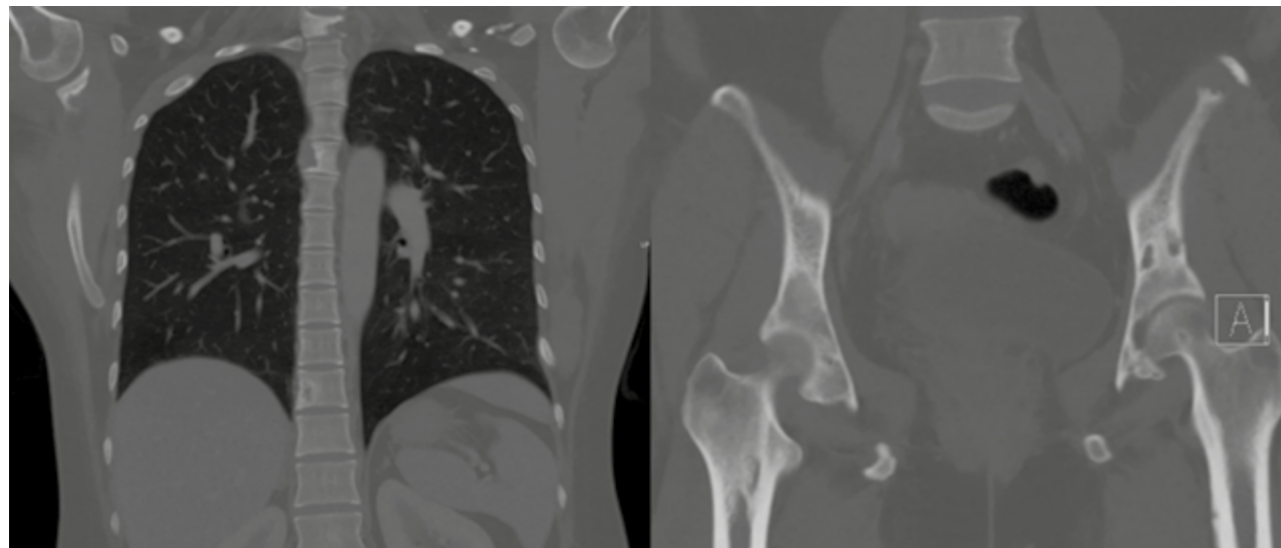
Coronal CT in bone window of the (a) Thorax and (b) Pelvis.
